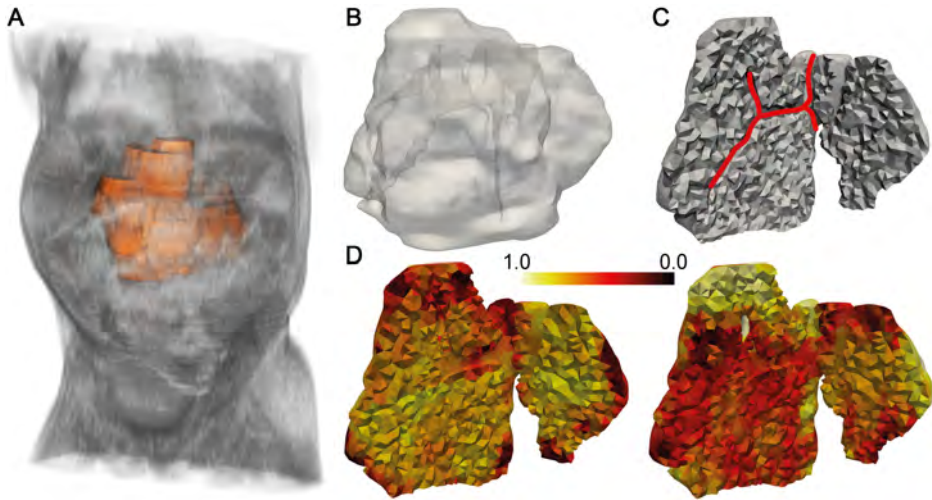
Application of the *im2mesh* library to one of the cases from the PRIMAGE dataset. A. Reconstruction of the tumor and the abdominal region of the patient using *3D Slicer* (whole stack of 50 slices). B. Surface mesh of the tumor generated using our library from the 17 slices containing the tumor. Through the semi-transparent surface, the mesenteric artery and some of its branches can be seen passing through the tumor. C. Volumetric mesh of the tumor with the aforementioned vessels highlighted in red. D. Normalized cellularity (left) and vascularization (right) maps interpolated from DWI and DCE sequences to the volumetric mesh presented in C.
